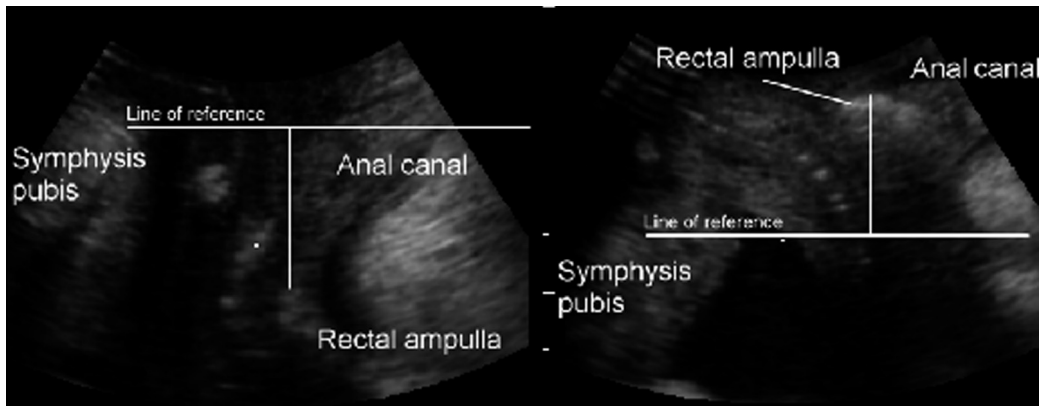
Rectal and/or perineal hypermobility without true rectocele as imaged on translabial ultrasound. The line of reference signifies the level of the inferior margin of the symphysis pubis. There is descent of the rectal ampulla below this level, without formation of a herniation into the vagina, as there is no discontinuity of the anterior wall of the anorectum similar to that seen in Figure 2. The transducer has been pushed off the symphysis pubis by the posterior compartment descent. This is admissible and will not alter measurements as long as the transducer is not angled.
